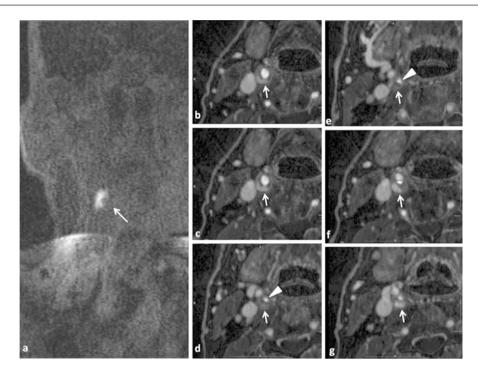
(a) Pre-contrast T1-weighted images show the presence of a hyperintense area in the right cervical region (*arrow*); (b–g) highresolution sequences acquired at the equilibrium phase demonstrate the presence of a severe stenosis of the right internal carotid artery
